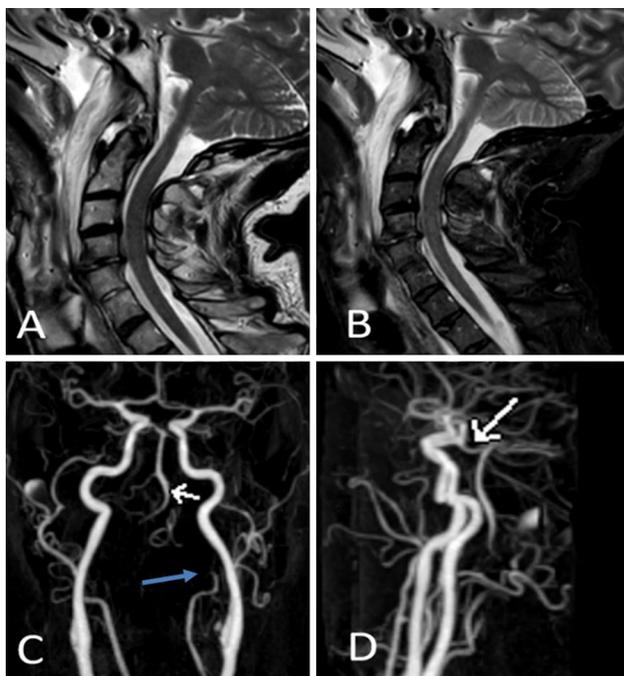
MRI cervical spine, mid-sagittal T2 weighted (a), mid-sagittal short tau inversion recovery (STIR) (b), anteroposterior view of 3D MR angiography (c), and lateral view of 3D MR angiography (d). There has been spontaneous reduction in the atlantoaxial dislocation. There is high signal within the cervical spinal cord as it passes posterior to the odontoid process and through the foramen magnum extending as far as C7, in keeping with contusion. There is no ongoing spinal cord compression. In (c) there is bilateral occlusion of the vertebral arteries at the level of C2 (blue arrow) with retrograde filling of the basilar and posterior inferior cerebellar arteries (white arrow). In (d) there is good collateral circulation via robust posterior communicating arteries (white arrow)
